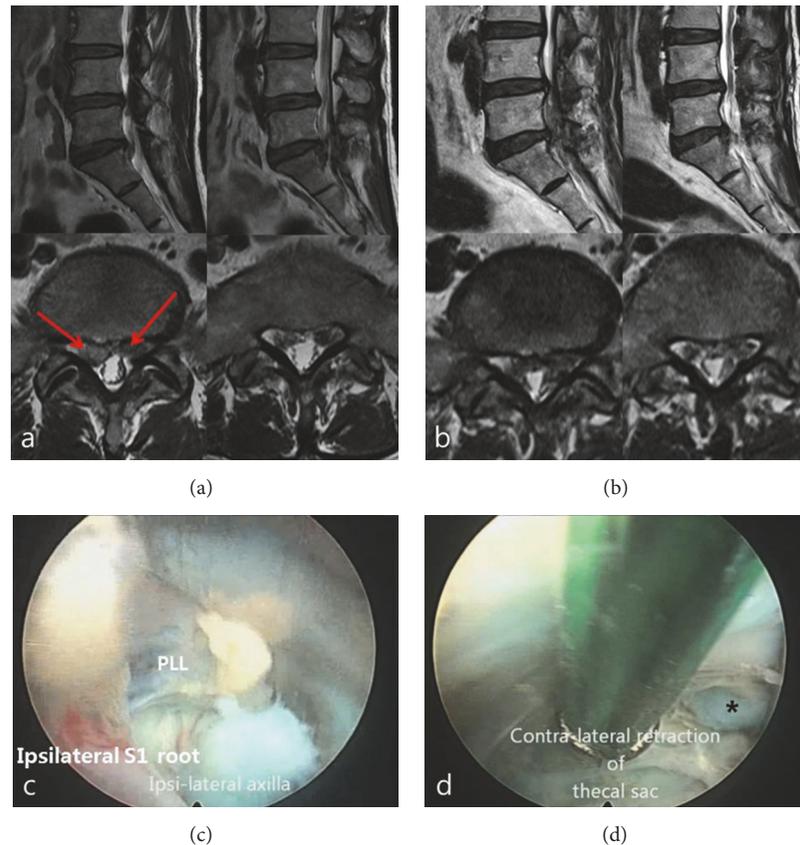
Bilateral disc herniations on L5-S1. (a) Preoperative sagittal and axial T2-weight MRI showing thecal sac compression due to L5-S1 bilateral disc herniations. Red arrows: bilateral disc herniations compressing thecal sac. (b) Postoperative axial and sagittal T2-weight MRI showing decompressed thecal sac and bilateral S1 root by removal of bilateral disc herniation at L5-S1. (c) Ruptured disc material seen at ipsilateral axilla area of S1. PLL: posterior longitudinal ligament. (d) Tip of contralateral ruptured disc was exposed by retraction of thecal sac. Asterisk: tip of the ruptured disc from contralateral epidural space.
